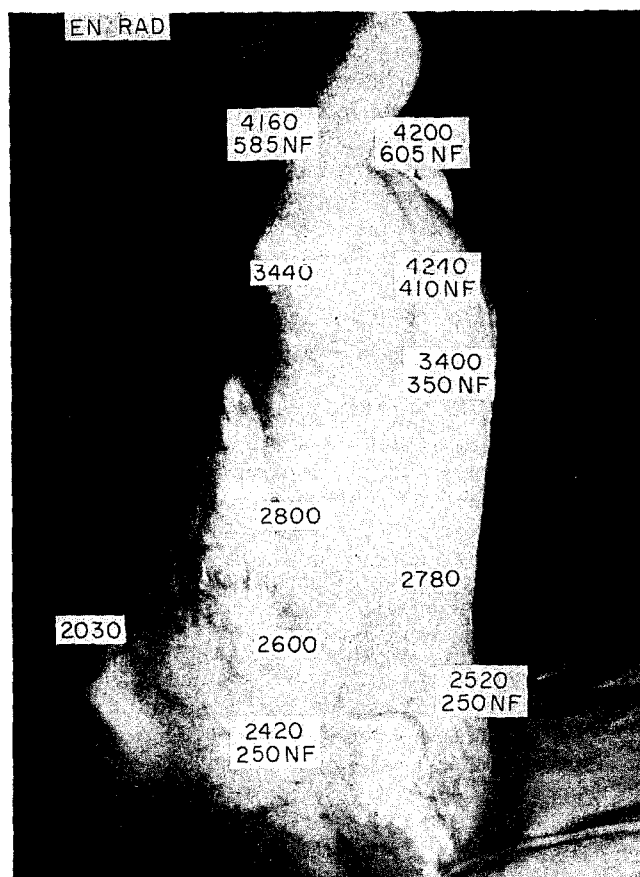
Doses gamma internes du pied sur radiographie. Voici les doses mesurées dans le fantôme du pied aux différents étages osseux; elles varient de 3.800 et 4.000 rads, au niveau des orteils et 2.000 au niveau de la cheville.
